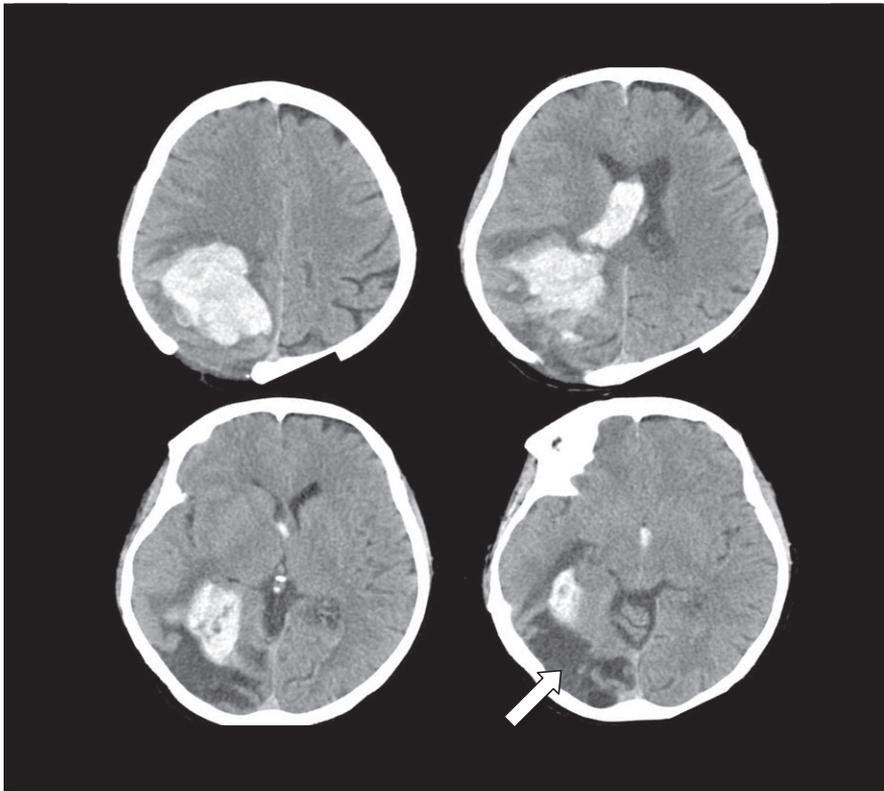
CT scan for recurrent intracranial haemorrhage presented: *New right parieto-temporal haematoma, with intra-ventricular flooding. Lower degenerative atrophic area (with arrow), outcome of previous haematoma of 2005*
